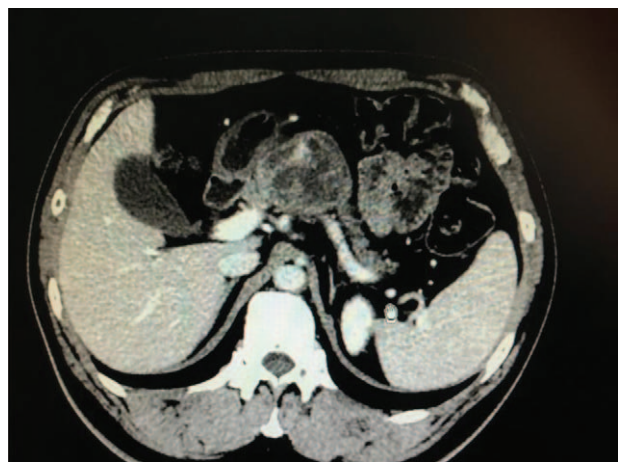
Enhanced CT scan of the MCN (portal vein phase). CT=computed tomography, MCN=mucinous cystic neoplasm.
